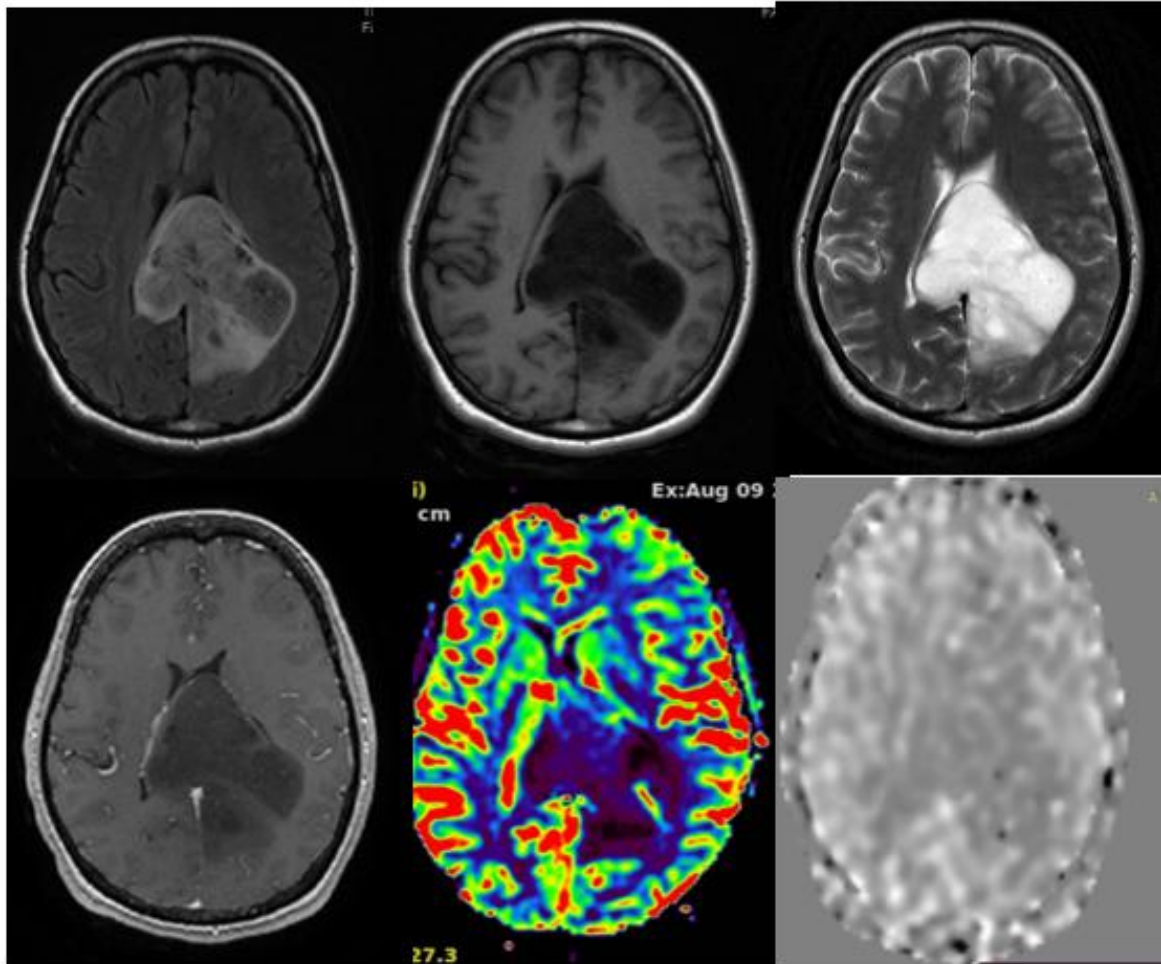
Case 2: MRI scan shows FLAIR axial image (top row left) with a heterogeneous hyperintense lesion in splenium of corpus callosum with extension on either side of midline. It appears hyperintense on T2WI(top row right) and hypointense on T1WI(top row middle) with T2/FLAIR mismatch. On perfusion imaging the lesion shows reduced perfusion. The values of normalised T2\*DSC perfusion rCBV( bottom row middle) in the region is 0.76. ASL perfusion (bottom
